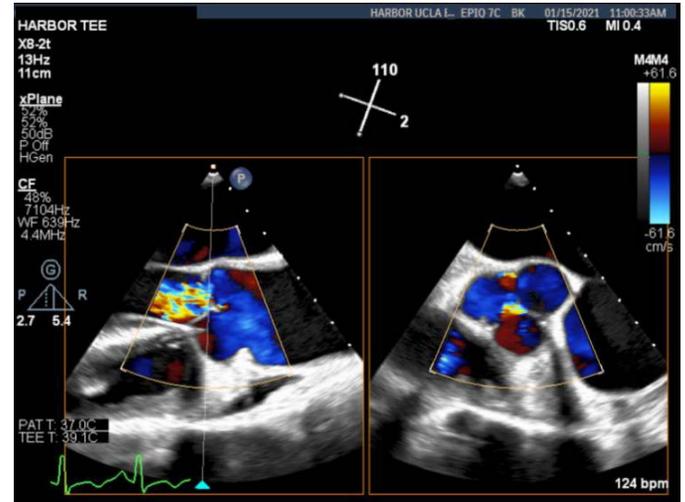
Transesophageal echocardiogram with color Doppler using X-plane across the aortic valve demonstrates a trileaflet valve with significant aortic regurgitation.
